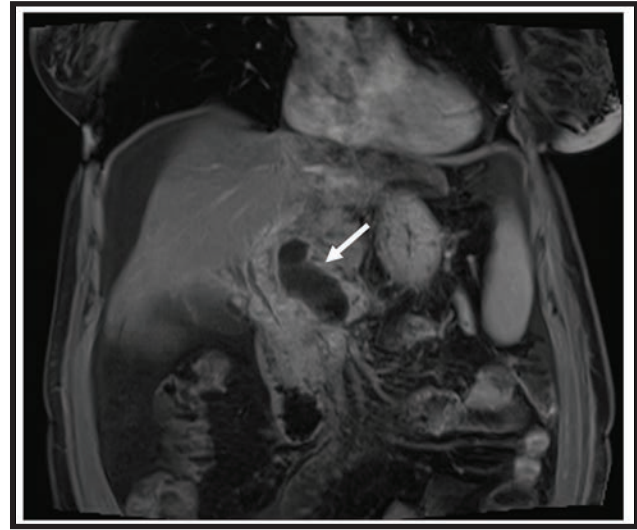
MRI demonstrating an enlarging fluid collection from a pancreatic duct leak at the pancreatic neck (arrow)
